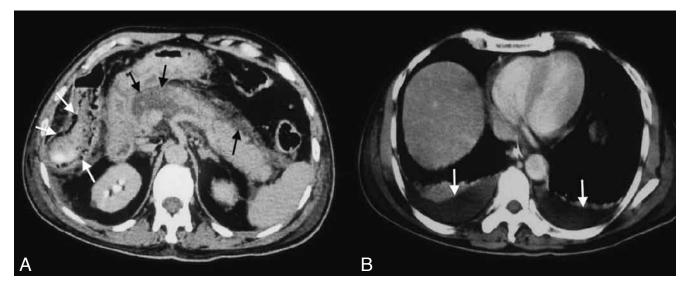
A. CT scan at the level of pancreas showed necrosis in head and neck region along with peripancreatic fluid (black arrows). Bowel wall thickening along with mural air can be seen within ascending colon and hepatic flexure (white arrows). B. CT scan at the level of lung base revealed bilateral pleural effusion with basal atelectasis (white arrows).
